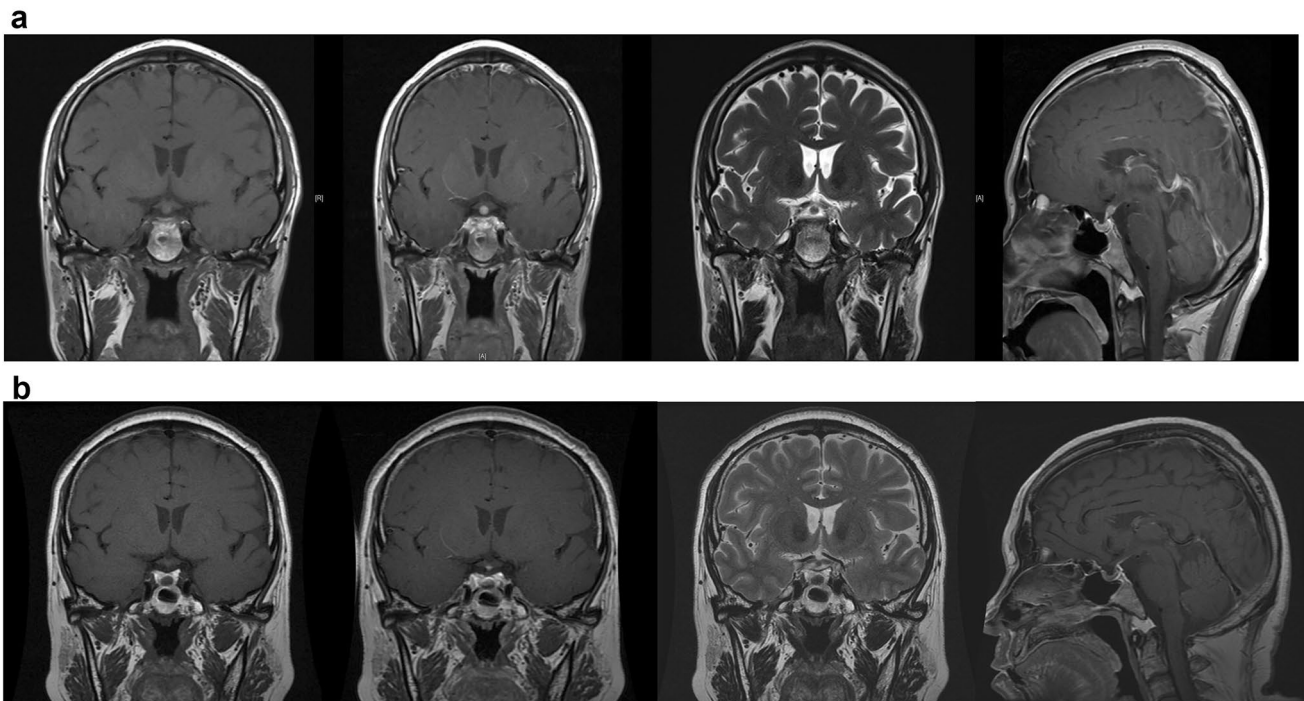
Pituitary MRI. a The upper end of the pituitary stalk was thickened, the high signal in the posterior pituitary disappeared, and the enhancement degree of the pituitary decreased. b One year after
